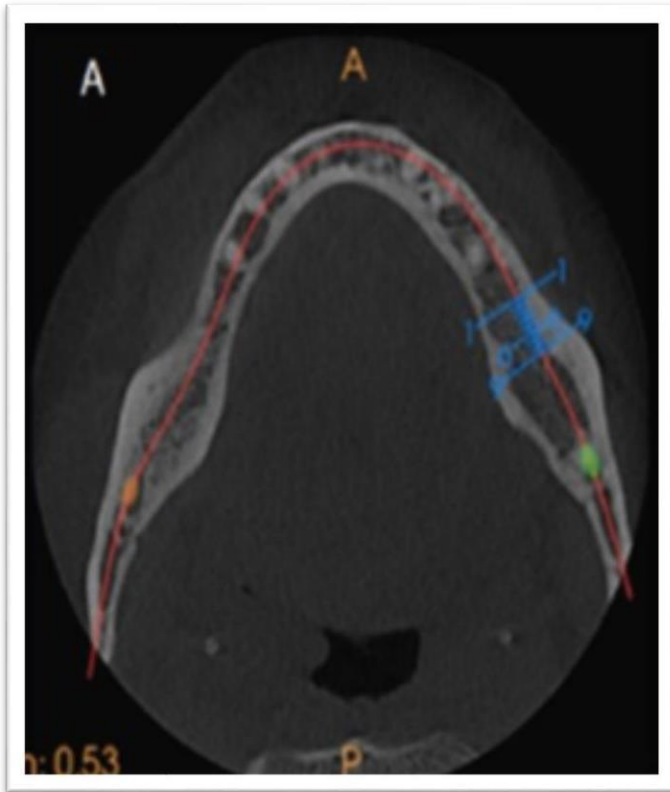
A). CBCT axial view with curved line for implant planning. Adapted from: Venkatesh E et al. (112)
